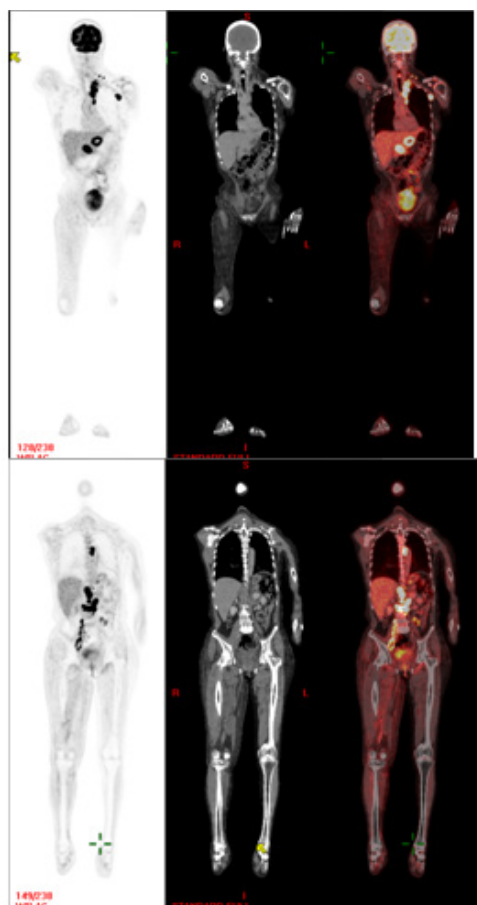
Coronal PET-CT.
